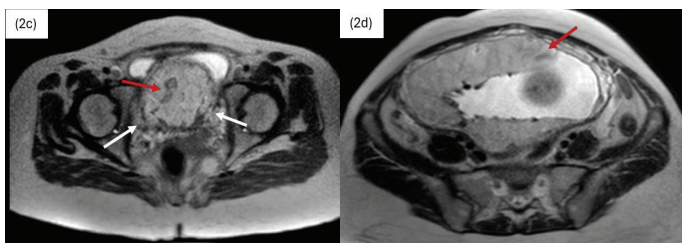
(a-d): MRI T2 WI shows heterogeneously hyperintense signal intensity of placenta (white star) It appears bulky and completely covers the internal os. Multiple T2-dark intraplacental bands (red arrow) seen with myometrial thinning and loss of retroplacental T2 hypointense line (yellow arrow). Urinary bladder appears collapsed with few T2-dark flow voids at placental-bladder interface (yellow arrow). There is evidence of bladder interface extension of placenta and extension along the posterolateral walls (white arrows) suggestive of placenta increta.
